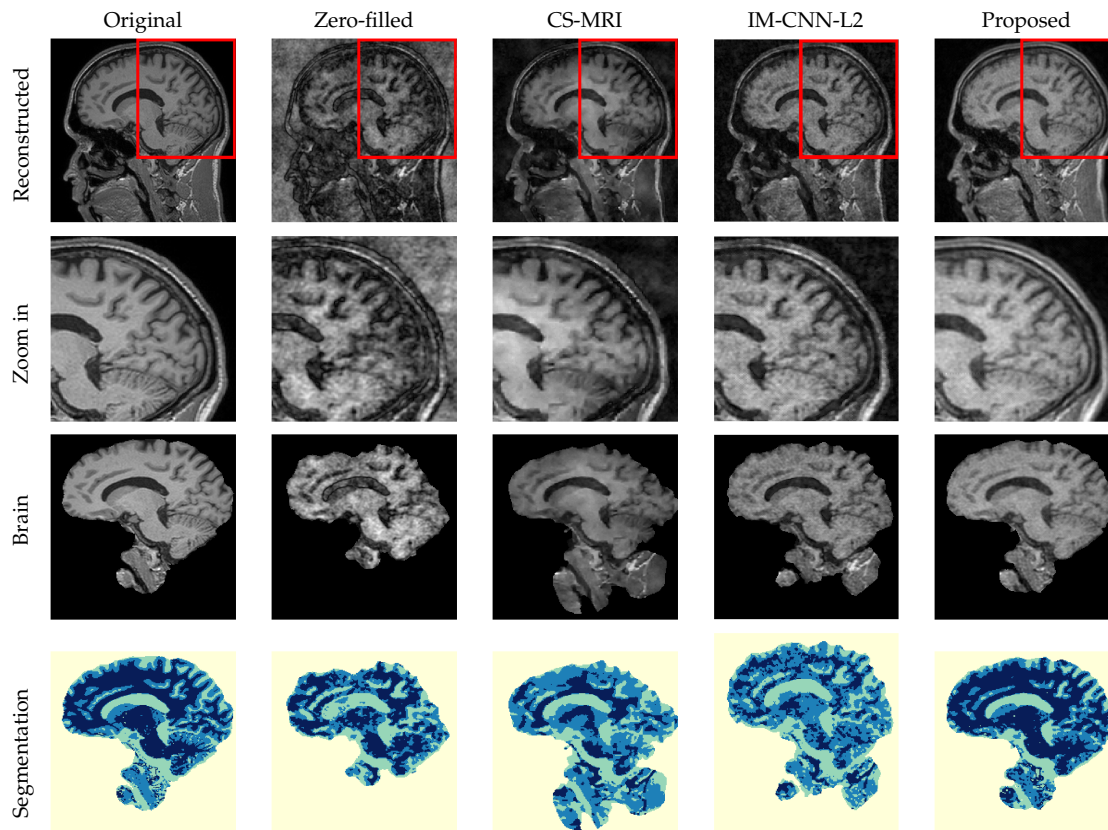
Examples of reconstructed MR images from under-sampled k-space - Factor 6.
